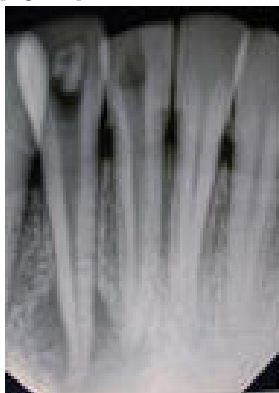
Radiograph showing root canal after retrieval of sewing needle fragment
